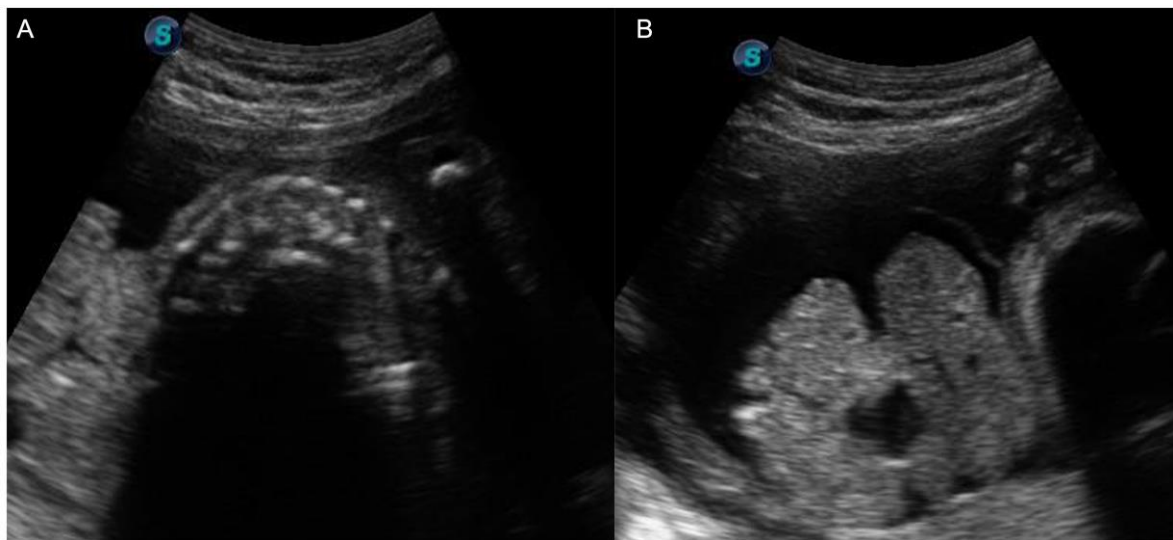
Ultrasound features of BSA Twin
